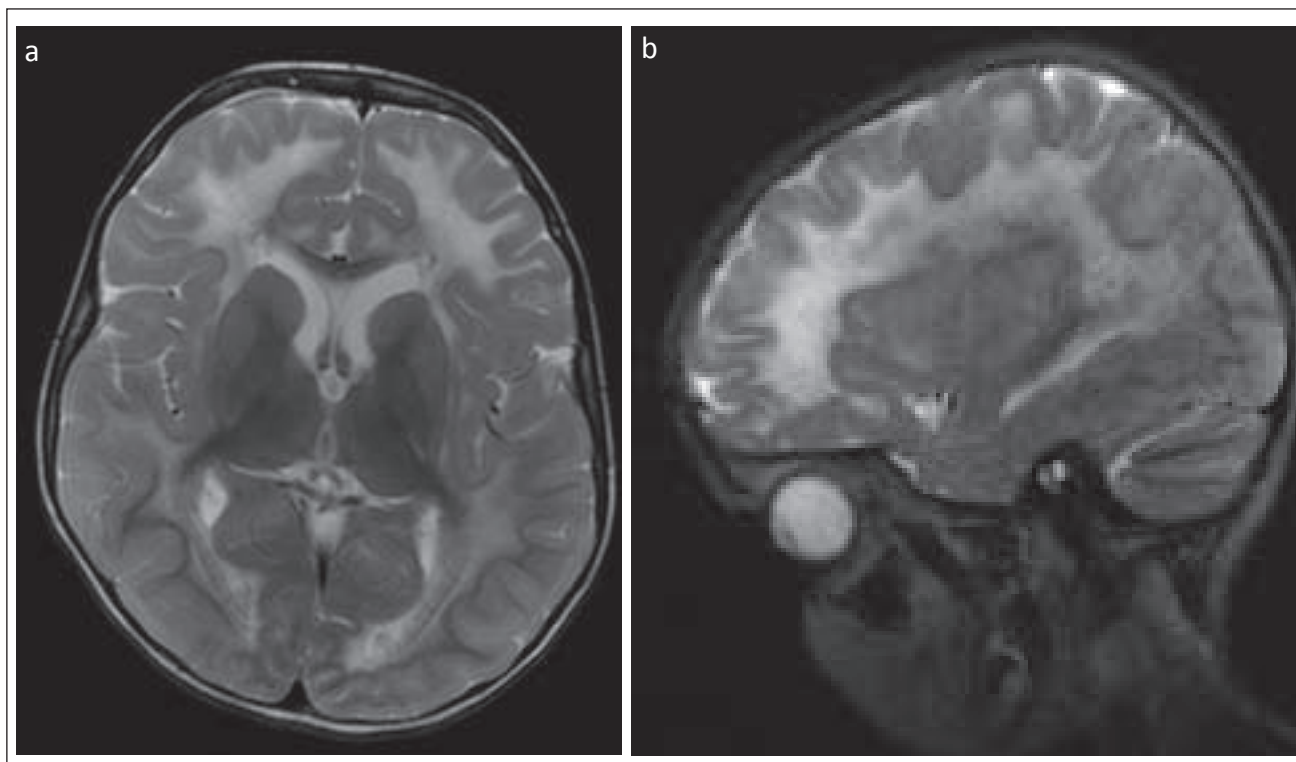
MRI of patient 3 with infantile/childhood form with more severe clinical course of the disease. Extensive white matter lesions with frontal predominance on T2 sequence, A – axial section, B – sagittal section.
